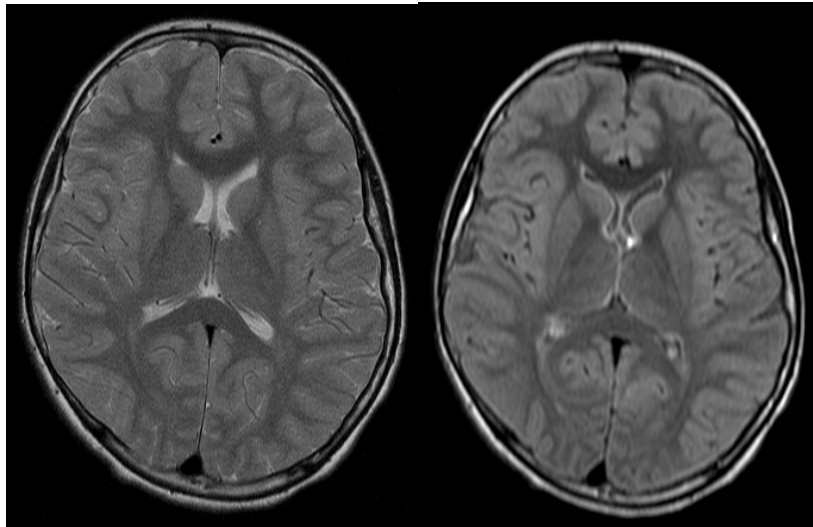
Comparison of T2-weighted FSE (left) and FLAIR (fluid attenuated inversion recovery) (right). The FLAIR sequence uses an inversion pulse with a TI of 2500 ms (at 1.5 T) which effectively suppresses signal from the CSF, leaving small peri-ventricular lesions more conspicuous.
